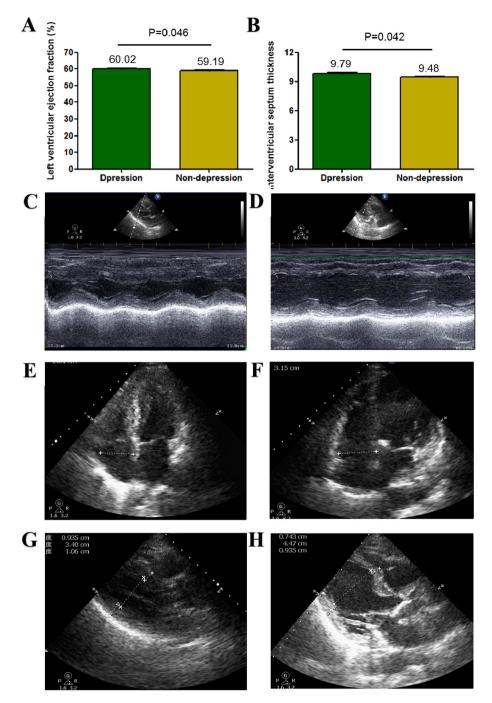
Left ventricular ejection fraction (LVEF) of centenarians with and without depressive disorder (A); Interventricular septum thickness (IVST) of centenarians with and without depressive disorder (B); LVEF of centenarians with depressive disorder in echocardiography (C); LVEF of centenarians without depressive disorder in echocardiography (D); IVST of centenarians with depressive disorder in apical four-chamber view of echocardiography (E); IVST of centenarians without depressive disorder in apical four-chamber view of echocardiography (E); IVST of centenarians without depressive disorder in apical four-chamber view of echocardiography (F); IVST of centenarians with depressive disorder in apical four-chamber view of echocardiography (F); IVST of centenarians with depressive disorder in left ventricular long-axis view of echocardiography (G); IVST of centenarians without depressive disorder in left ventricular long-axis view of echocardiography (H).
